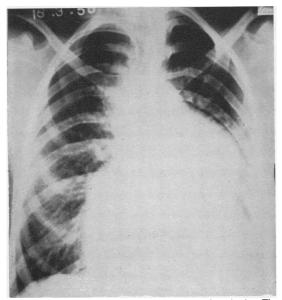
Postero-anterior radiograph a month before death. The general cardiac enlargement and the aneurysmal dilatation of the pulmonary artery are well seen. The lack of vascularity in the periphery of the lung fields is most obvious in the upper lobes in this reproduction.
